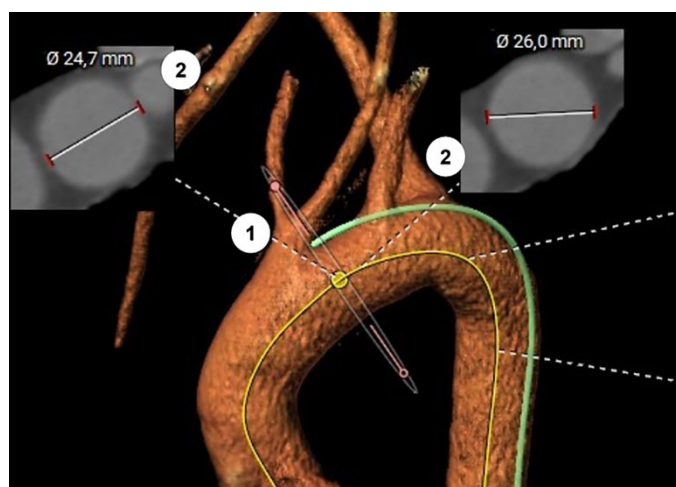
Computed tomography angiography of the aortic arch and supra-aortic trunks.
